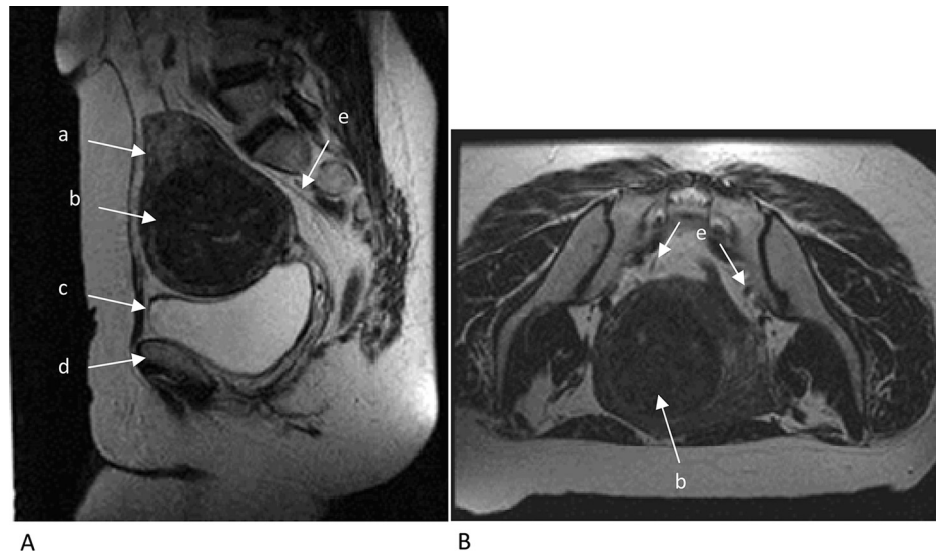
(A) T2-weighted sagittal scan image. (B) T2-weighted axial scan image for preprocedure planning. The sensitive regions such as pubic bone, bowel and nerves (arrows) were marked to ensure safety of MRgFUS ablation. a = uterus; b = uterine fibroid; c = urinary bladder; d = pubic bone; e = sacral nerve. MRgFUS = magnetic resonance-guided focused ultrasound surgery.
